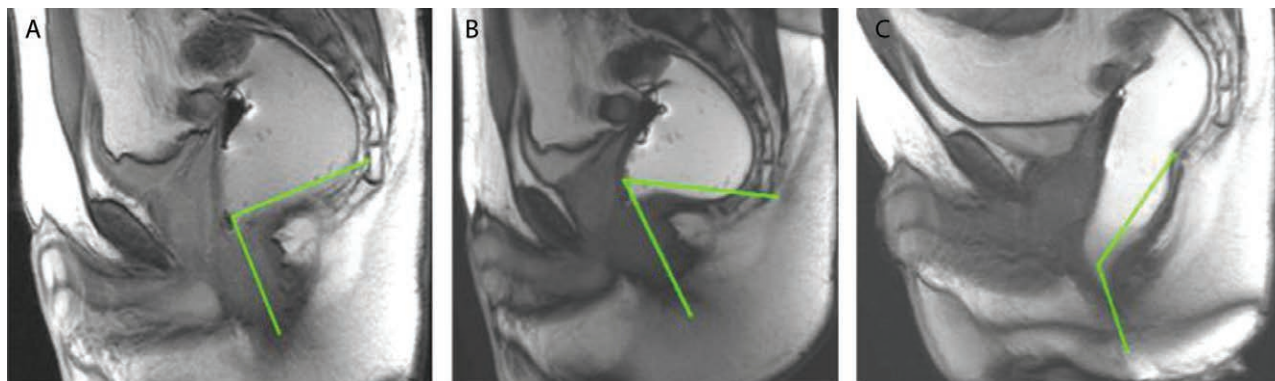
Anorectal angle. A, Images at rest: the anorectal angle is measured from the midline of the anal canal to a tangent to the posterior rectal wall. B, Images with squeeze: normally the anorectal junction narrows. C, Images with evacuation: normally the anorectal junction widens. Reprinted with permission from Magnetic Resonance Imaging Clinics of North America 2013;21:427–445.
